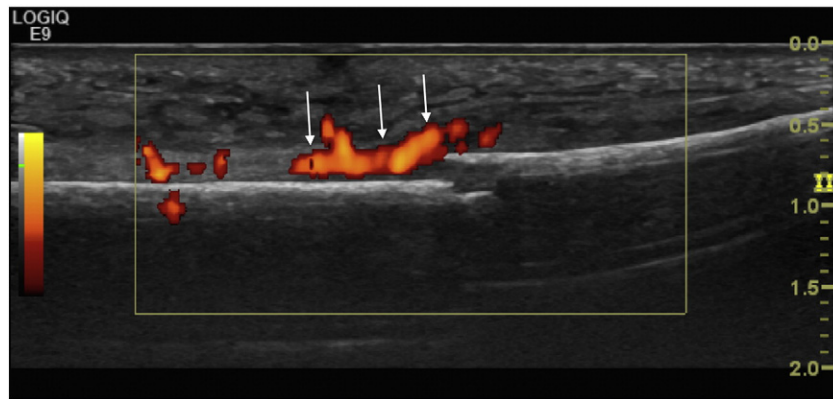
Power Doppler imaging demonstrates active vascular response at the site of fracture.
